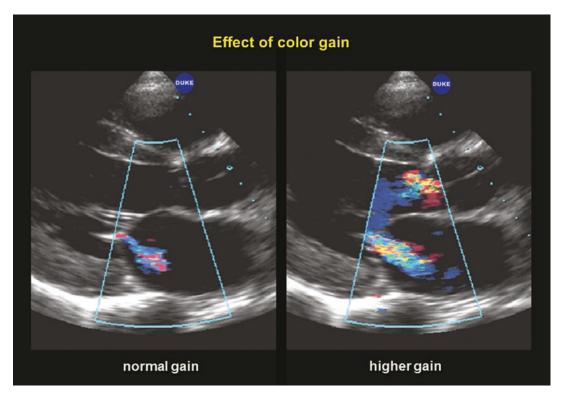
Parasternal long axis from a patient with a centrally directed small degree of mitral regurgitation that in increased in size with an increase in color gain
